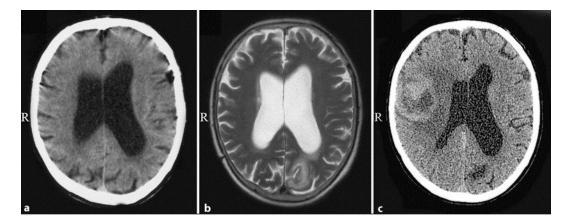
Neuroimaging of case 2. CT and MRI scans 2 months before the admission (a, b), and CT scan just prior to surgical intervention (c).
